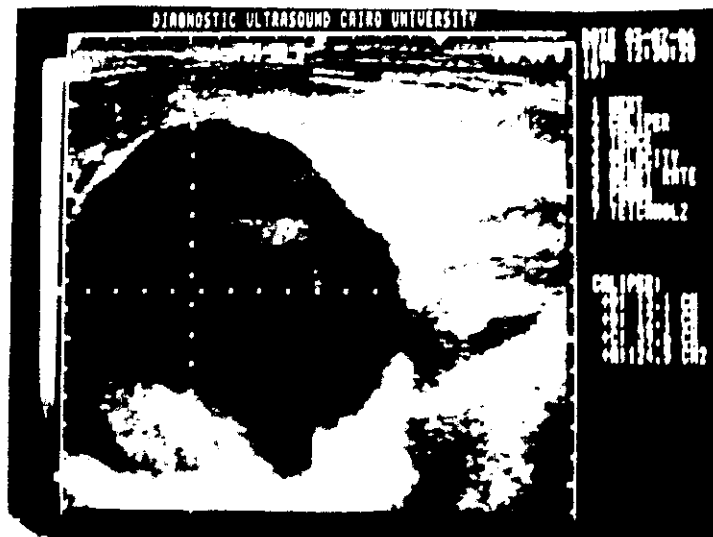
Real time ultra-sonography scan shows a cyst, echoes inside the cyst representing debris or daughter cysts, diagnosed as hydatid cyst.
